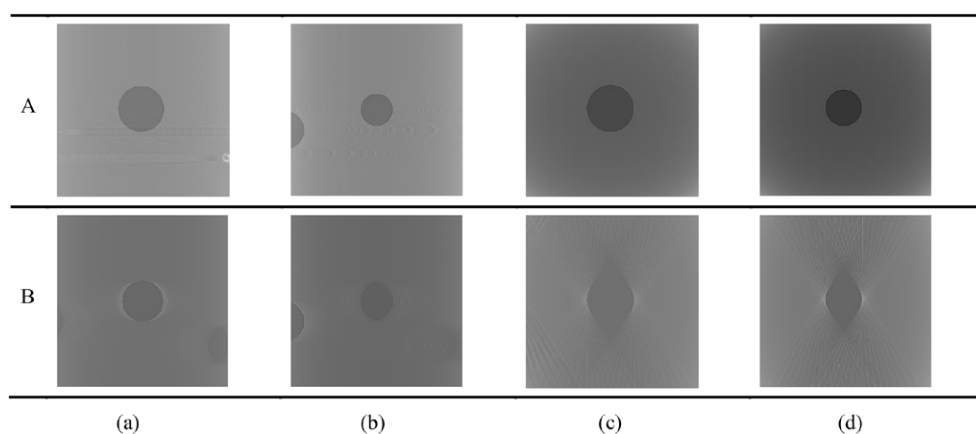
Comparison of ((a) and (b)) coronal and ((c) and (d)) axial reconstruction planes obtained from PhC projection images in (A) CT mode and (B) tomosynthesis mode at different depths in the reconstructed sphere: (a) and (c)—reconstructed slices corresponding to the central plane of the spherical object, (b) and (d) reconstructed slices corresponding to planes 2 mm away from the central plane. Inherent tomosynthesis artifacts are seen in images in (B).
